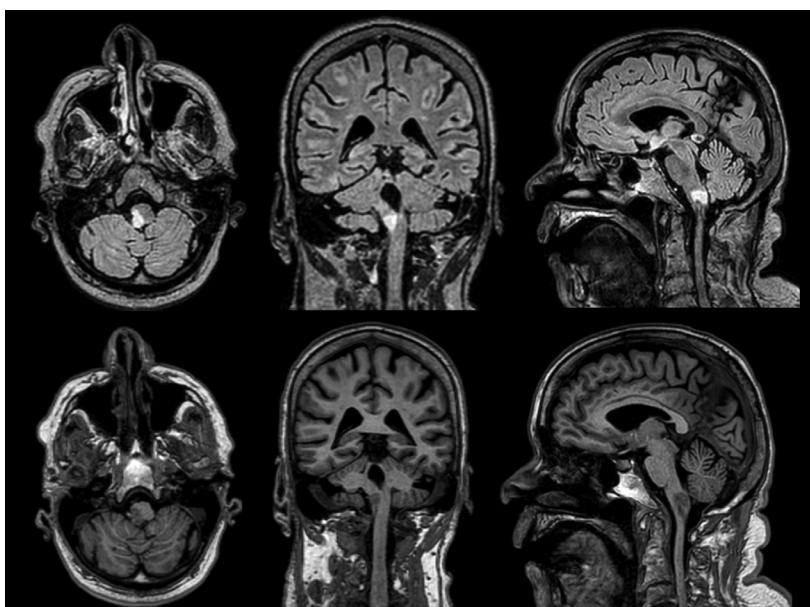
MRI of the brain, axial, coronal, sagittal sections are presented. Infratentorially in the brainstem a high-signal at FLAIR (above) – lesion with axial size 13/9 mm, involving the medulla oblongata and pons. Same with hypointense signal pattern at T1 (bottom)
